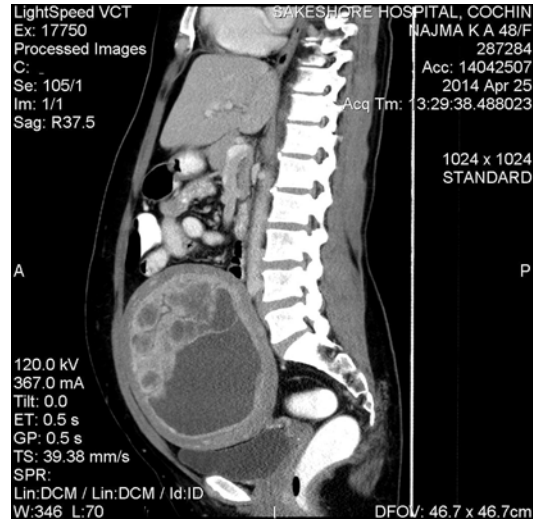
CT scan showing enlarged uterus with cystic spaces and thinned out myometrium
